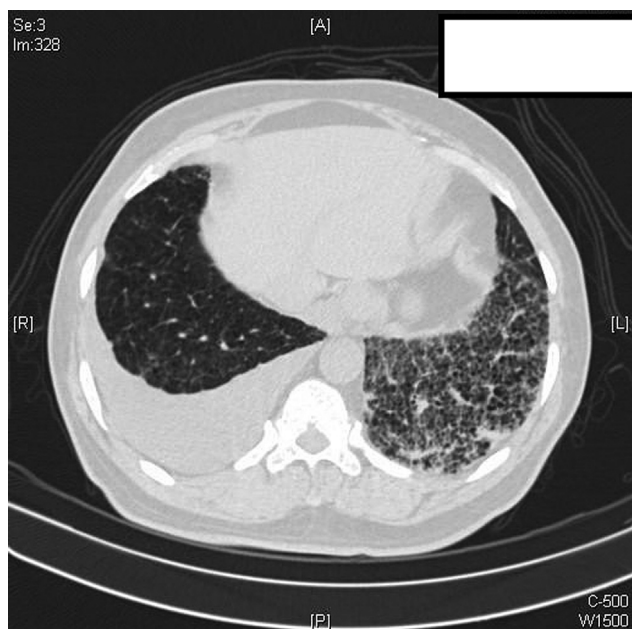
High-resolution chest CT scan: interlobular septal thickening and ground-glass opacities in the left lower lobe along with right-sided pleural effusion on a background of centrilobular emphysema.
